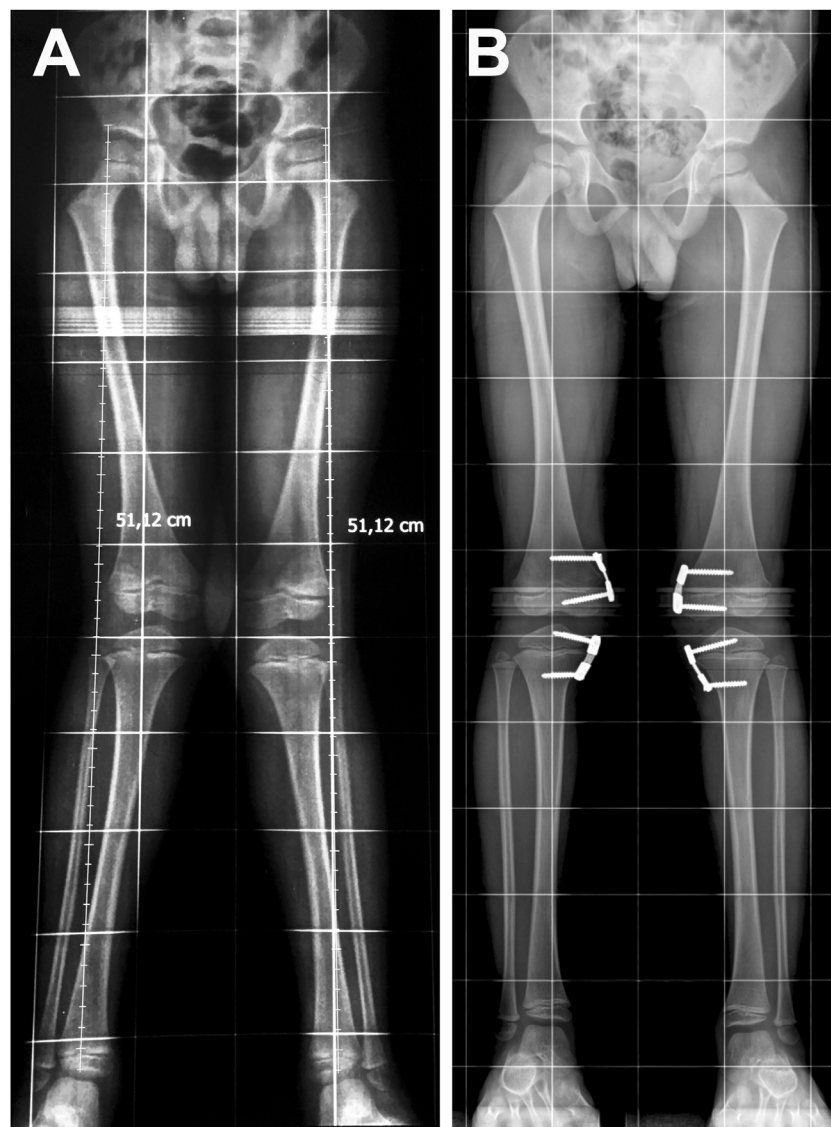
Presurgical X-rays (A) of a 4-year-old patient with idiopathic genu valgus with a MAD in zone -3. Post-surgical X-rays (B) show the anatomical angles correction and normalization of the MAD to zone 1.
